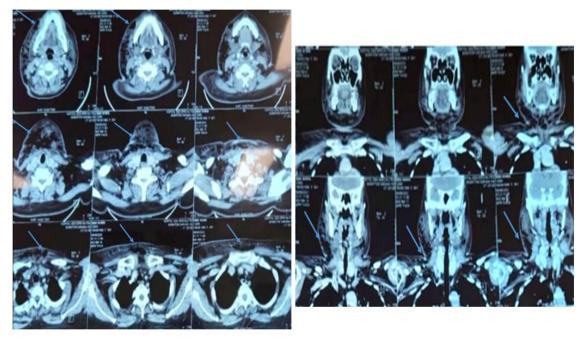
Cervicofacial CT scan with evidence of the collection and presence of gas involving cervico-thoracis spaces
